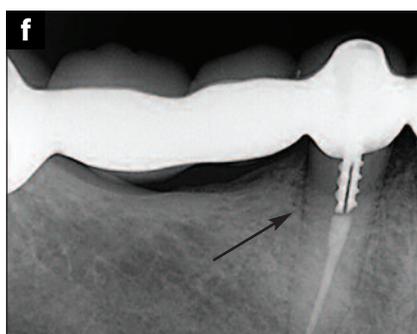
Generalized coronal periodontal breakdown could be seen on the 2-dimensional (2-D) periapical radiograph.
